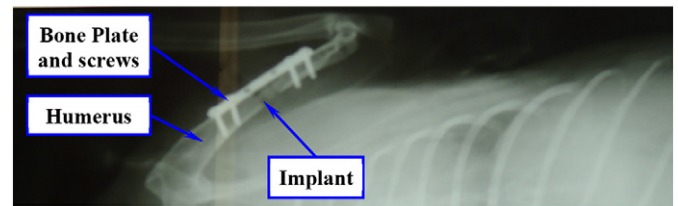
Radiographic photo of the humerus after surgical operation to check and confirm the implant position (Day 0).
